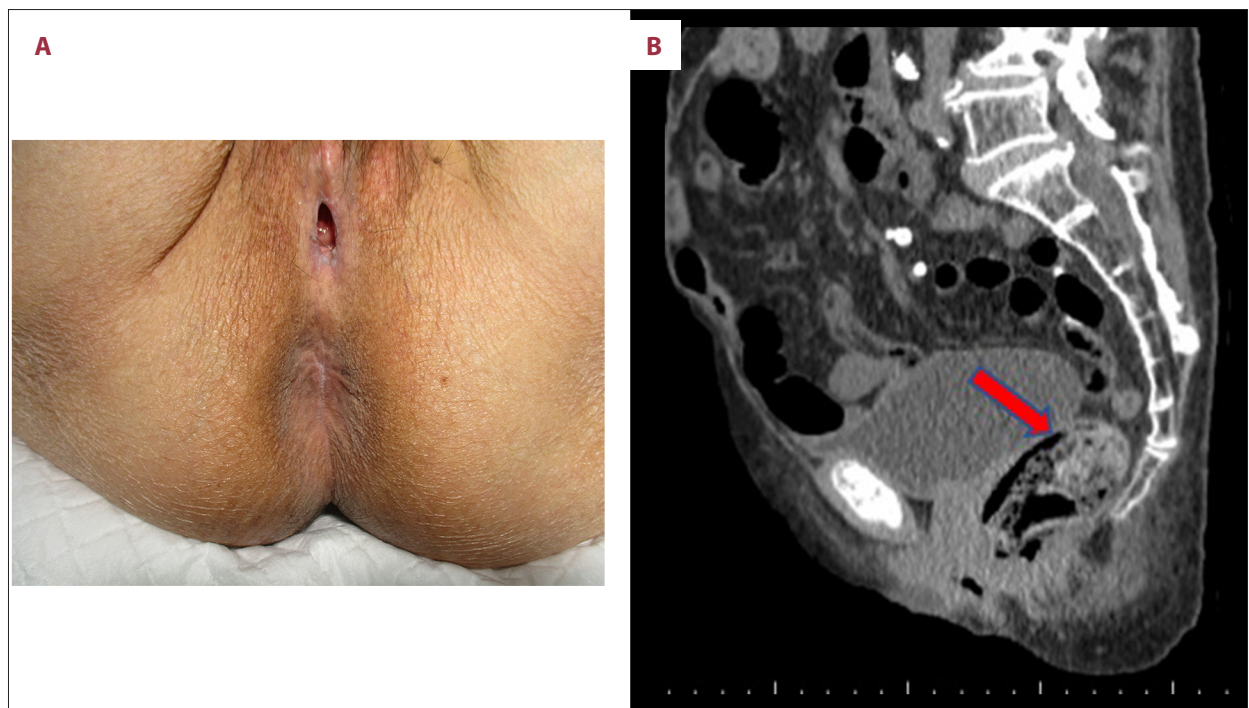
The patient's anus covered with normal skin and fully obstructed. The patient's labia show adhesions. The vagina and external urethral openings are not obstructed (A). Sagittal view CT scan with arrow pointing toward the diverted rectum filled with stool and gas (B).
